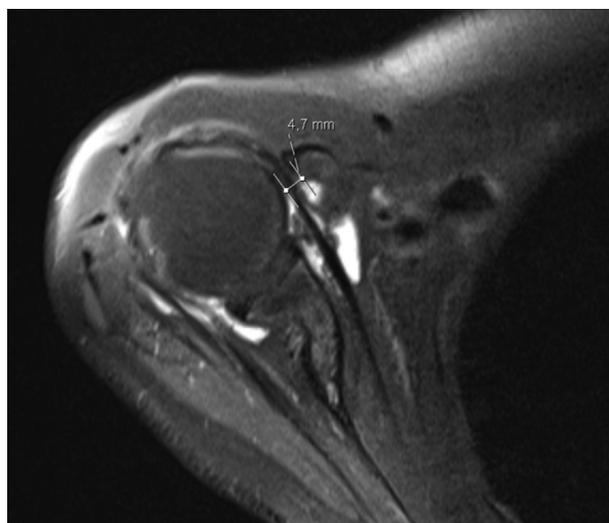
Transversal section of T1-weighted magnetic resonance image showing coracohumeral distance—minimal distance between humeral and coracoid cortices.
